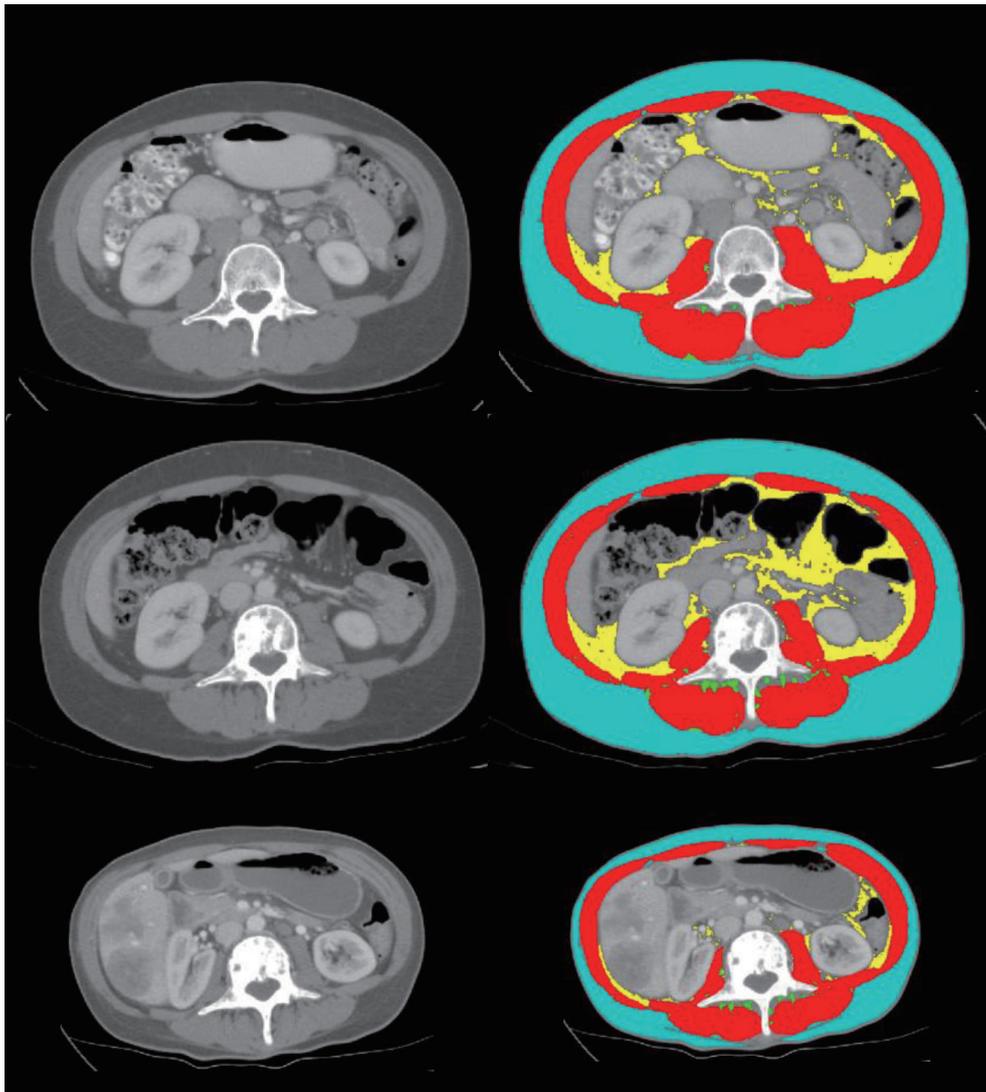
Computed tomography defined progression of cancer cachexia. Left: axial CT images at the 3rd lumbar vertebra are shown for a female patient with metastatic breast cancer. Right: images are annotated for skeletal muscle (red) including the psoas, paraspinal, quadratus lumborum, lateral and oblique abdominal and rectus abdominis, as well as fat [visceral (yellow), intermuscular (green) and subcutaneous (light blue)]. Scans were taken at diagnosis (top), 2 years later at start of year of death (middle), and during the last month of year of death (bottom).
